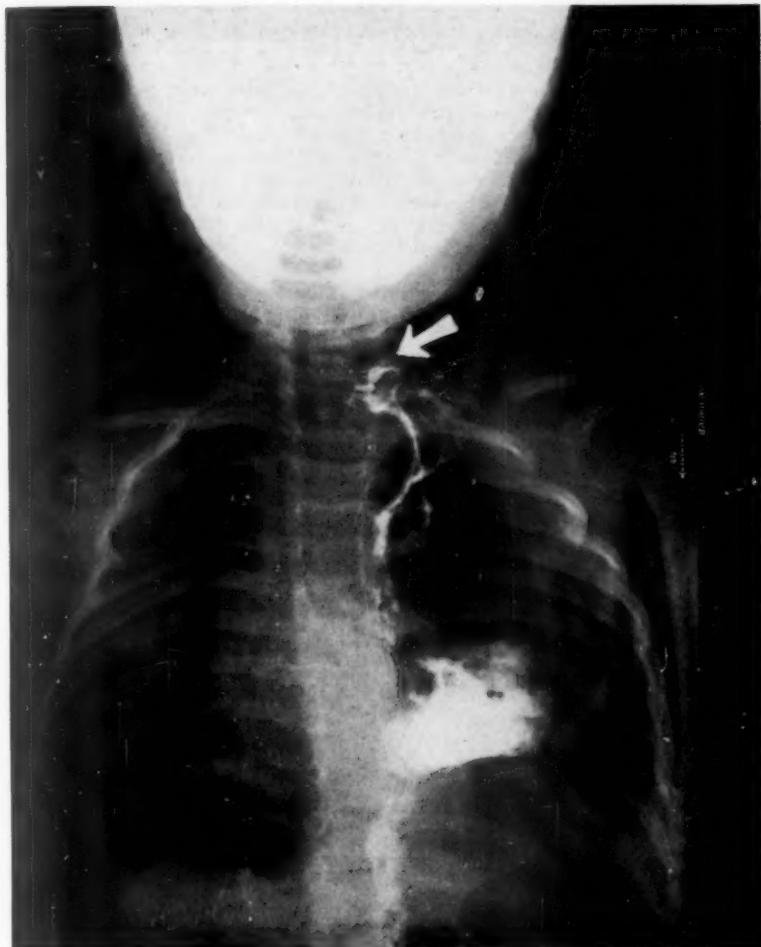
Case W. C. Postoperative roentgenogram after ingestion of barium. The anastomosis is indicated by the arrow. Just below are the rugal folds of the fundus of the stomach. The remainder of the stomach as it lies in the left pleural cavity behind the hilum of the lung contains air and a small amount of barium. The cut ends of the first rib and clavicle are easily seen. The lung lies around and to the side of the stomach.
